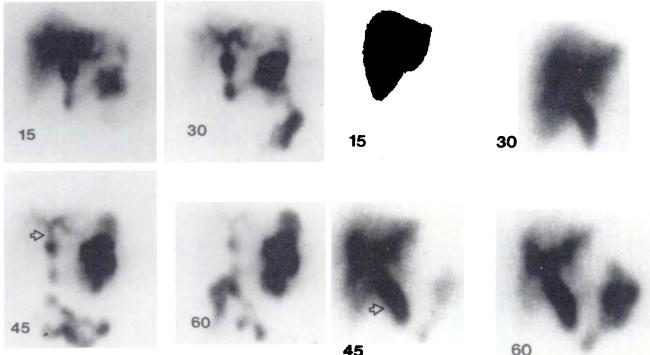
Hepatobiliary scintigram in a normal postcholecystectomy patient (sphincter pressure: 15 mmHg). (1) There is marked activity in the bowel by 15 min. Bile ducts and bowel were actually visualized in earlier images (not shown). (2) By 45–60 min, the biliary tree does not appear prominent. After 30 min, the CBD becomes progressively thinner and fainter. (3) The CBD at 60 min is slightly more active than the liver at 60 min, but much less than liver at 15 min.
